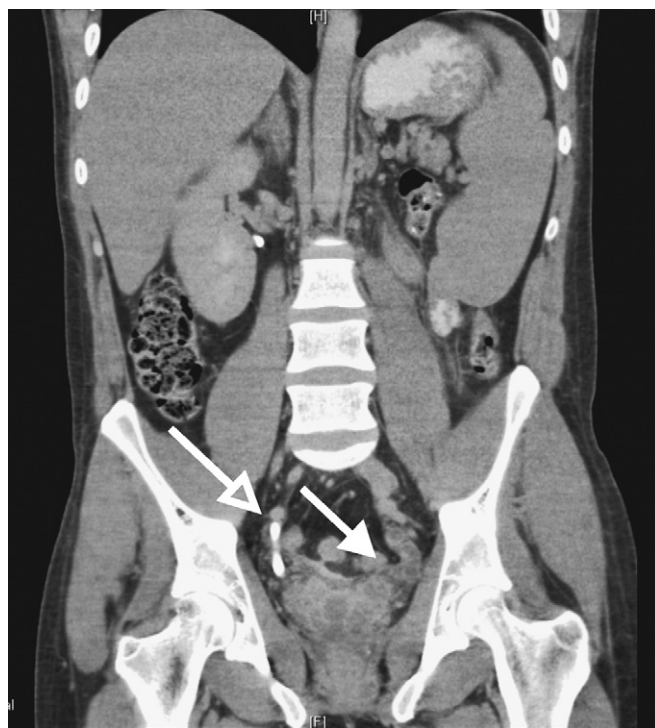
Coronal computed tomographic image of the abdomen and pelvis obtained in the delayed phase. The right kidney is shown with contrast exiting via the right ureter and continuing down immediately lateral to the dilated seminal vesicles (open arrowhead). A lack of contrast excretion from the left kidney along with a dilated left ureter inserting into distended seminal vesicle cysts (solid arrowhead) are shown.
